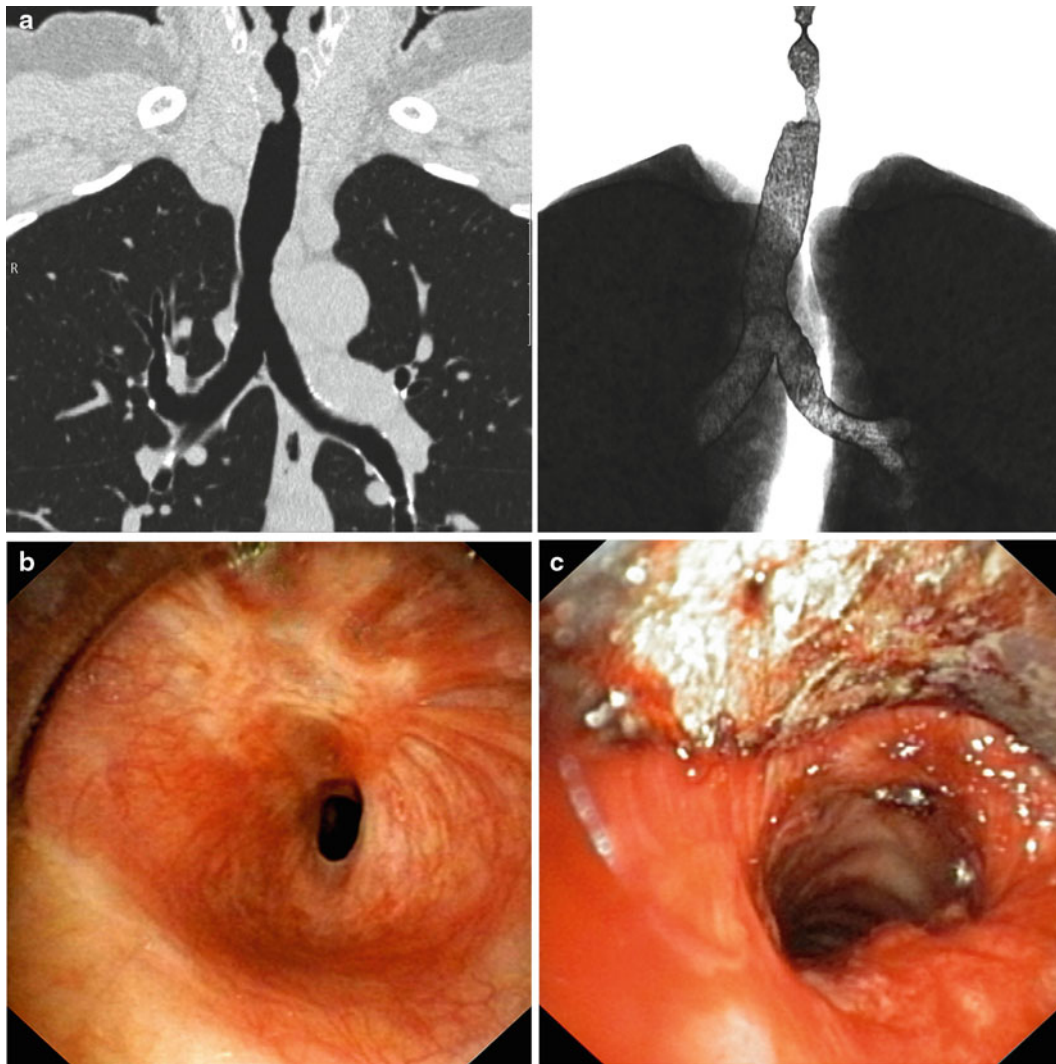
CT coronal image and 3D reconstruction of a patient with >1-cm-length idiopathic subglottic stenosis (a). Bronchoscopy revealed a complex stenosis, Myer-Cotton grade III (b). Nd:YAG laser radial incisions followed by balloon dilatation restored airway lumen (c)
